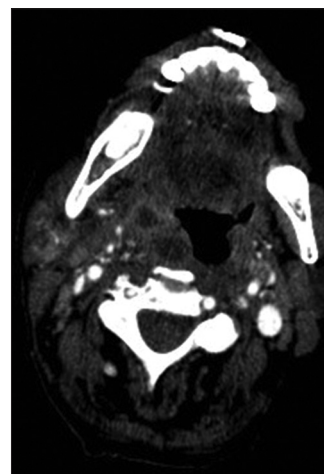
Computed tomography axial projection of the oropharynx shows an abscess in the right parapharyngeal space
